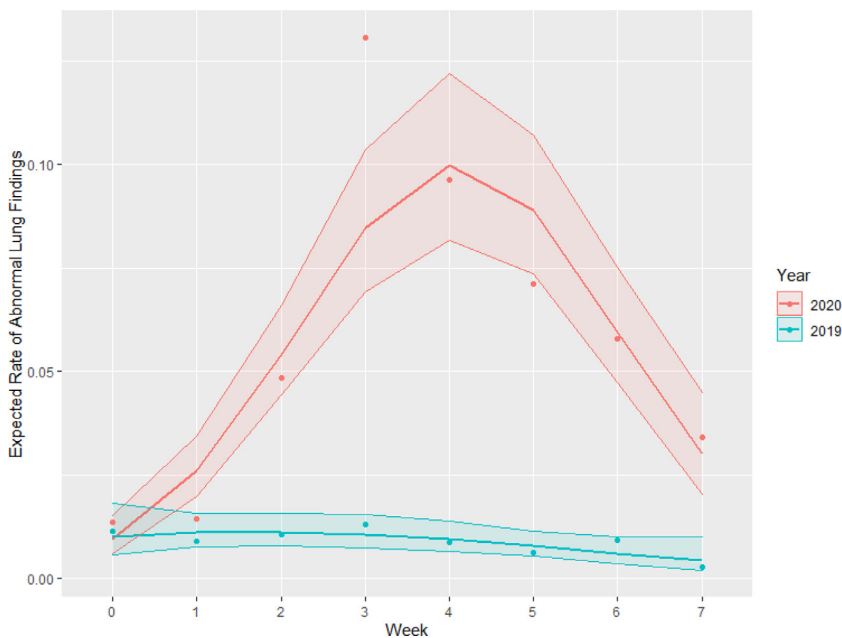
Expected rate of abnormal lung base findings on abdominopelvic CT over time, comparing March 8, 2020 to May 2, 2020 and March 8, 2019 to May 2, 2019, showing distinctive rise during COVID-19 outbreak. (Color version of figure is available online.)
